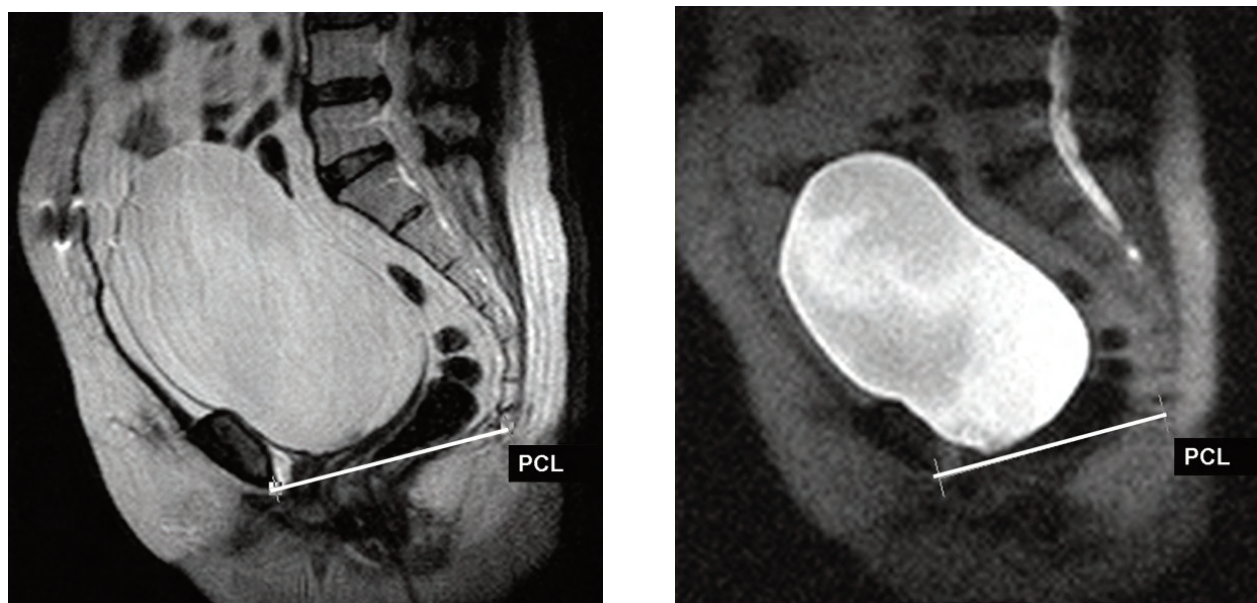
A 51-year-old postoperative asymptomatic woman (the severity score of incontinence, 0). Sagittal T2-weighted MR image at rest (A) and sagittal modified T2-weighted MR image on maximal straining (B), showing no significant bladder neck descent (PCL: pubococcygeal line).
